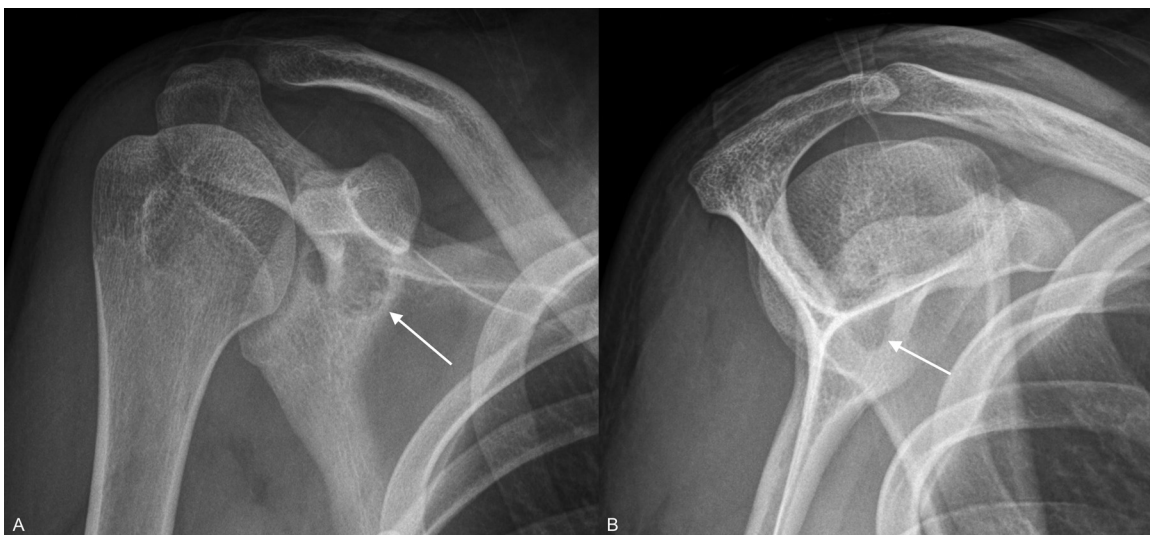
Shoulder X-ray AP and oblique view. (A-C) A lytic intraosseous lesion is observed in the neck of the scapula without periosteal reaction or soft tissue mass.
